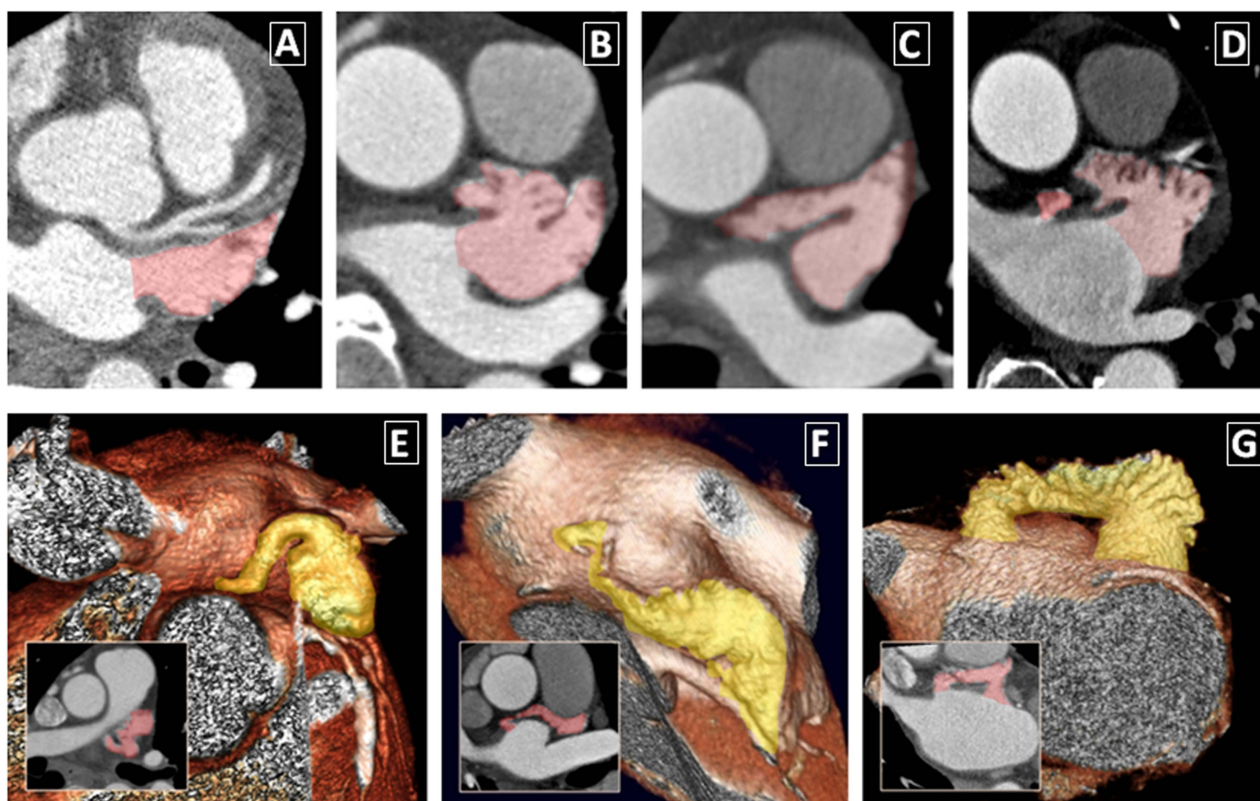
Morphological variations of the left atrial appendage (LAA). (A–D) Axial CT images at the neck of the LAA showing common variants of the LAA. (E, F) Sculpted volume rendered CT views of the left atrium along with inlay axial 2D images at the level of the LAA showing three rare variants of the LAA. The LAA is colour coded. The most common variant is the LAA with two lobes (B, D). It is not uncommon to see that the tip of the LAA is medially rotated (C, E). Small accessory appendages arising from the anterior wall are not uncommon (D) and in rare instances may connect to the tip of a medially rotated LAA (F, G). Panels C, E, and F are not candidates for an epicardial approach to percutaneous LAA exclusion.
